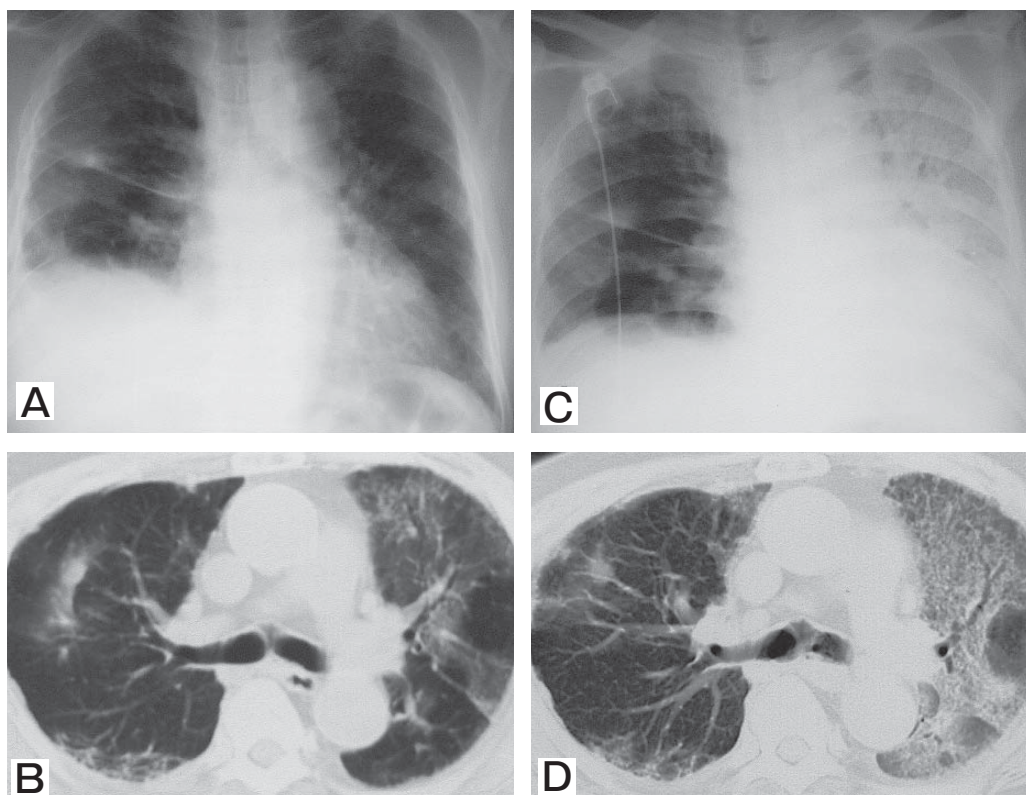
A, Chest radiograph shows diffuse shadows in the left middle and lower lung fields; B, CT scans of the chest demonstrate ground-glass opacities; C, D: Chest radiograph and CT scans of the chest showed extensive areas of ground-glass opacities and traction bronchiectasis. The distribution was predominantly in the lower zone.
